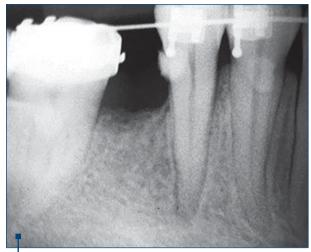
Tooth 45 – preoperative radiograph
